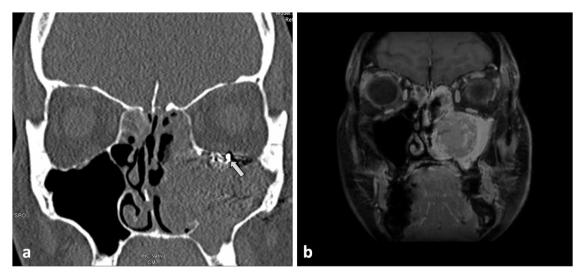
(a) CT scan of the paranasal sinuses (coronal view, after embolization) showing the tumor in the left sinus system; the medial wall of the maxillary sinus is destroyed; the infraorbital artery is embolized by opaque Onyx[®] (white arrow); (b) MRI scan of the head showing the paraganglioma in the left sinonasal tract.
